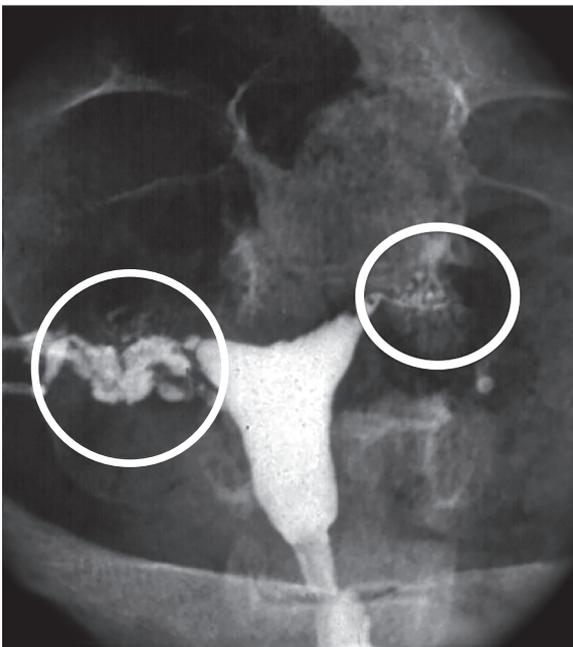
Case 03 - Patient with a history of left tubal pregnancy. The radiography shows multiple saccular formations, in the isthmian cornual portion in both tubes (contained inside the white circle). The uterine tube is totally opaque with peritonization of the contrasting medium (Cotté positive proof), while the left tube is completely obstructed (Cotté negative proof).
